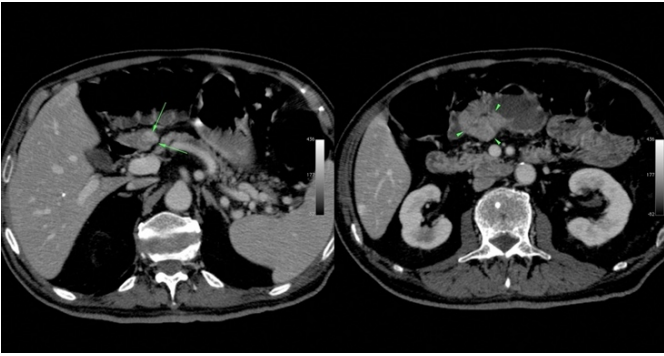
A solid, round shaped, well-defined mass (arrows) located in the gastric wall and another mass (arrow heads) that resulted in symmetrical thickening of the wall at the level of small bowel in contrast-enhanced sections as shown by abdominal computed tomography
